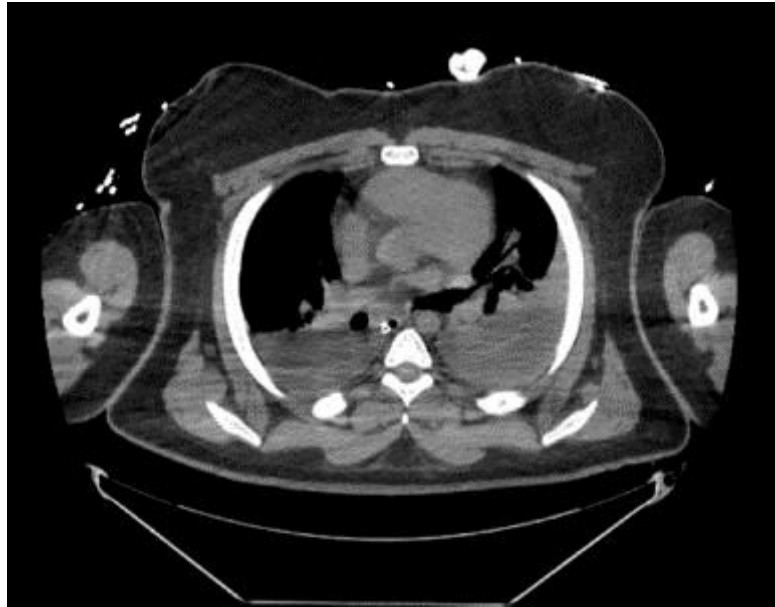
CT of chest on ICU day 1 demonstrated posteriorly layering bilateral pleural effusions (left greater than right) with adjacent atelectasis of bilateral lower lobes.
